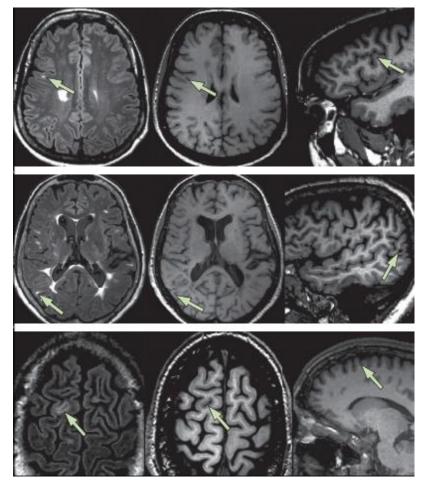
Cortical and juxtacortical lesion detection with MRI
